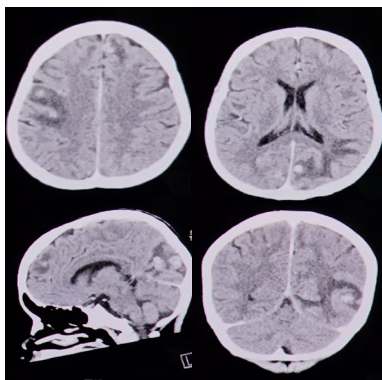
Contrast-Enhanced CT Scan of the Brain (Axial, Sagittal, and Coronal Views).
